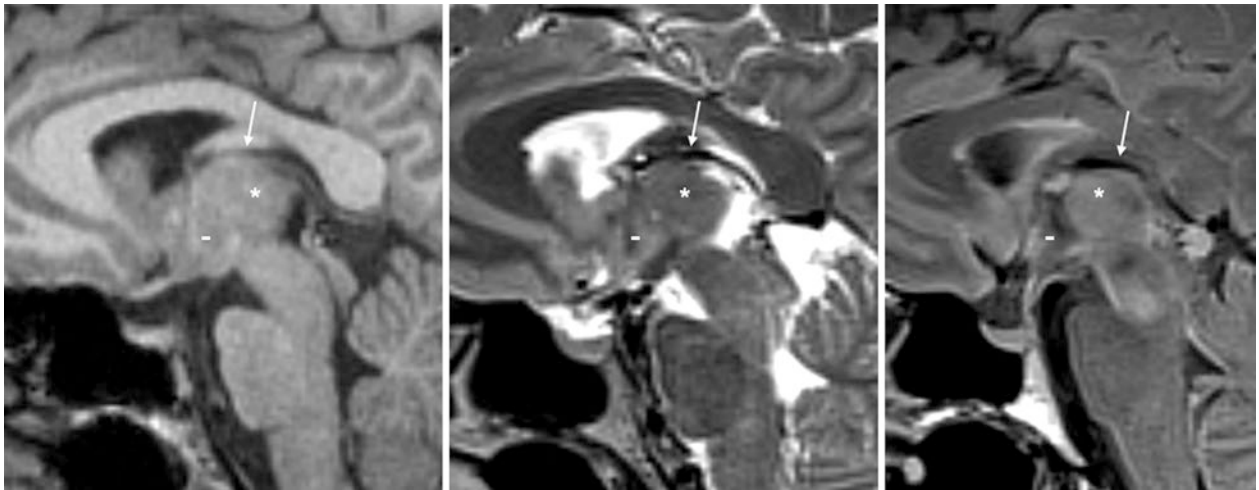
A 25 year old who underwent a 3T MRI performed as part of a research study; it demonstrated a mass intermedia pseudomass (*) on a midline sagittal T1WI (left), T2WI (middle), and FLAIR (right). This appears mass-like as a result of CSF flow artifacts in the third ventricle (-) on T1WI and T2WI, which disappear on FLAIR. Note the internal cerebral veins (arrows)
